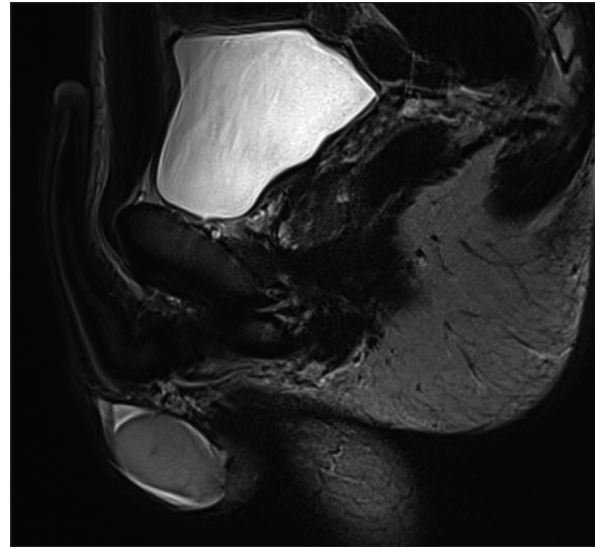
Pelvic MRI of the patient – normal data.
